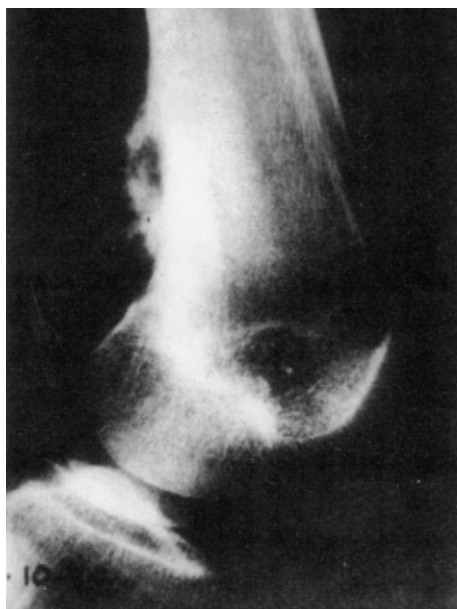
The first X-ray of the knee (at the age of 17 years): mass of the lower one third of the femur, dense, relatively well limited, attached to the metaphyseal cortex by a wide base.
